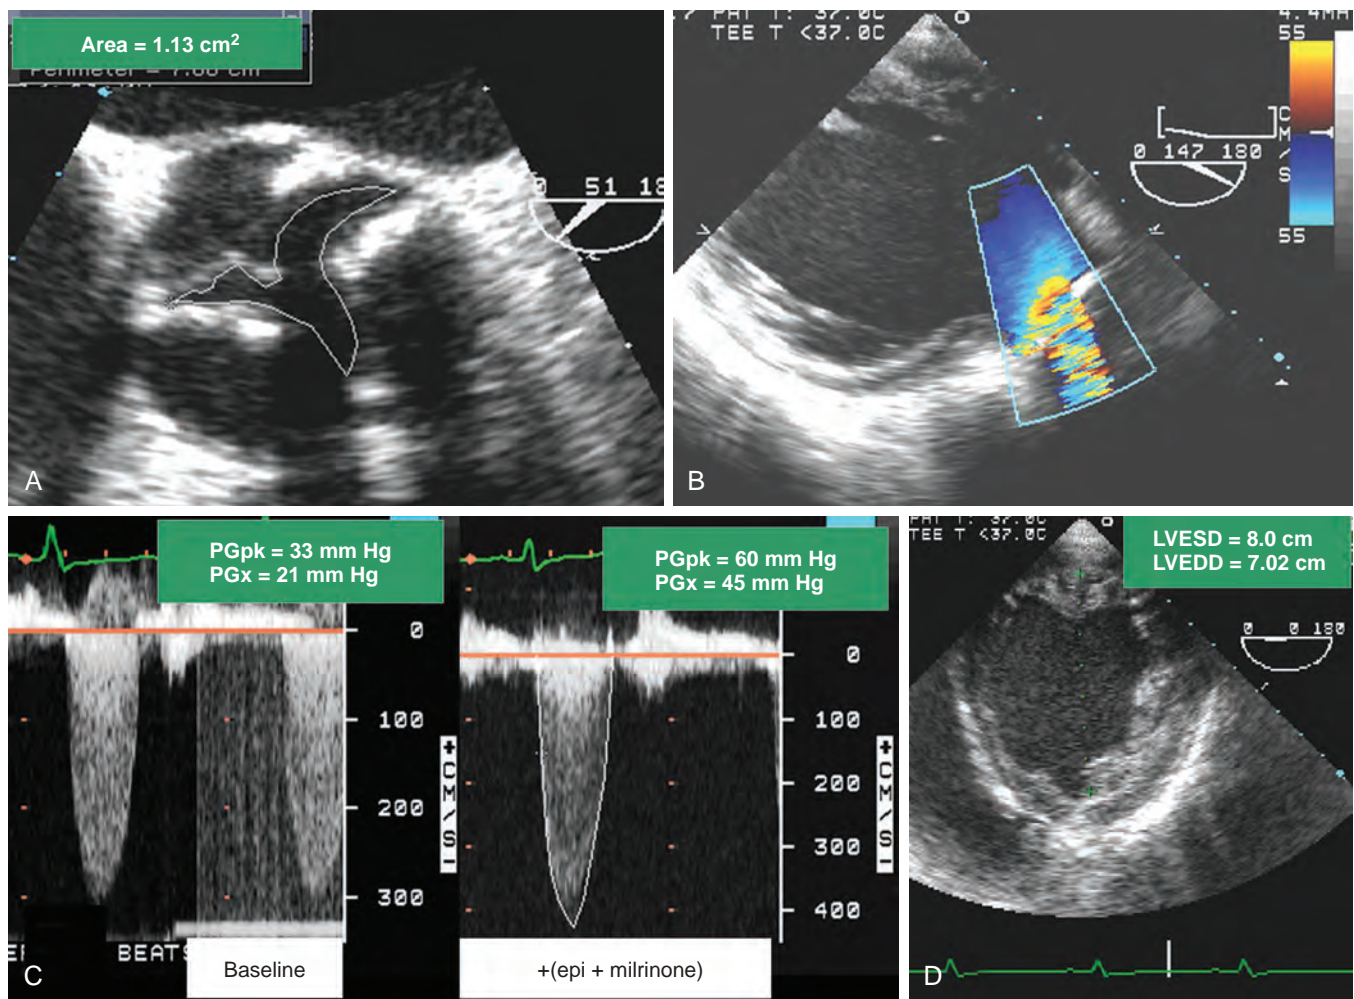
Low-pressure gradient severe aortic stenosis (AS). A 76-year-old cachectic man was scheduled to undergo a corrective surgical procedure for severe mitral regurgitation (MR) and possibly clinically significant AS. (A) The midesophageal short-axis view of the aortic valve (AV) showed a highly calcified trileaflet valve with restricted mobility. The measurement of AV area, 1.13 cm^2 , which was obtained by planimetry, was believed to underestimate the severity of AS because of the shadowing artifacts related to the severity of calcification. (B) The transgastric long axis of the left ventricle (LV) was obtained, and the velocity profiles of blood flow within the left ventricular (LV) outflow tract and the AV were measured. (C) Although the patient had a diagnosis of severe AS, the maximal pressure gradient (PGpk) and mean pressure gradient (PGx) were 33 and 21 mm Hg, respectively. The area of the AV was calculated to be 0.83 cm^2 using the continuity equation. (D) LV function was characterized by severe dilated cardiomyopathy with an ejection fraction of 8%, an LV end-systolic dimension (LVESD) of 7 cm, and an LV end-diastolic dimension (LVEDD) of 8 cm. The diagnosis of low-pressure gradient AS was considered, and infusions of epinephrine and milrinone were started. Cardiac performance improved from 2.4 to 4.5 L/minute, and the pressured gradients (C) increased to 60 mm Hg peak and 41 mm Hg mean. Although the calculated valve area that was recorded under conditions of inotrope support slightly increased to 0.9 cm^2 , transesophageal echocardiography clarified that the marked increase in the pressure gradient was consistent with a diagnosis of low-gradient AS and confirmed the presence of cardiac reserve.
